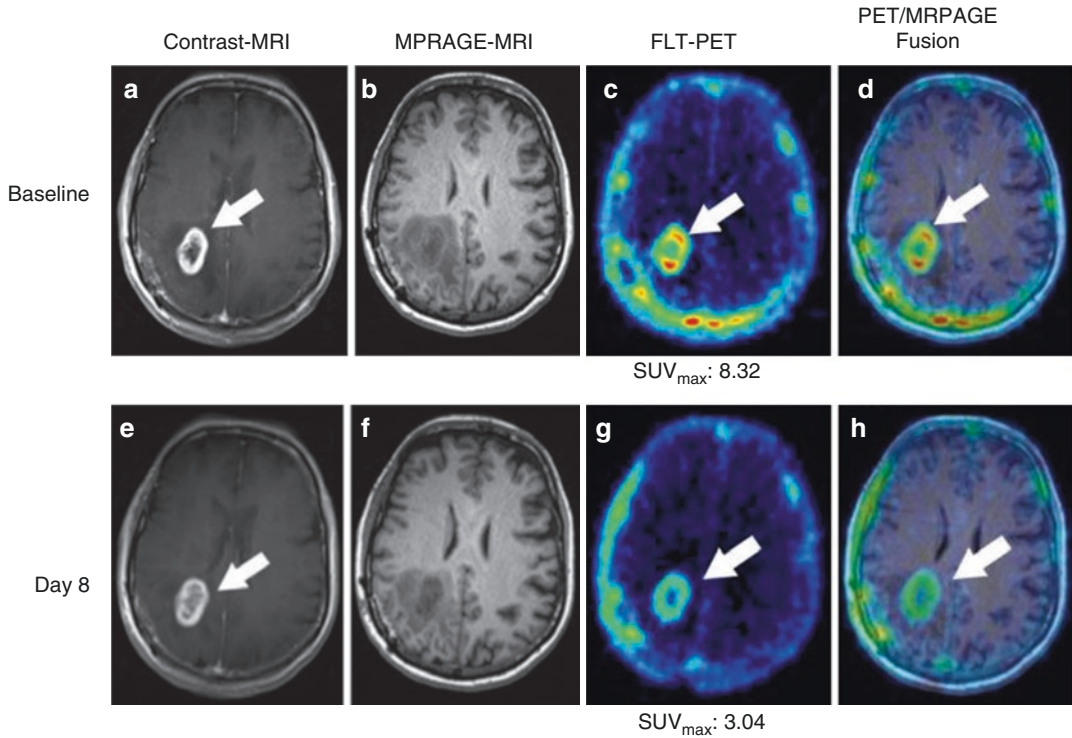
A 64-year-old female patient diagnosed with glioblastoma multiforme of the right parietal lobe, proven by surgical biopsy. ^{18}F -FLT-PET/CT scans were performed 40 min after injection of 185 MBq ^{18}F -18 3'-deoxy-3'- ^{18}F -fluorothymidine (FLT) with a 30-min acquisition, followed by gadolinium-enhanced MRI [1] (a) T1-weighted MR images. (b) Magnetization-prepared rapid acquisition with gradient echo (MP-RAGE) MR images, arrows). The baseline ^{18}F -FLT-PET/CT scans (c) show high uptake with $SUV_{max} = 8.32$. (d) PET-MR fusion
